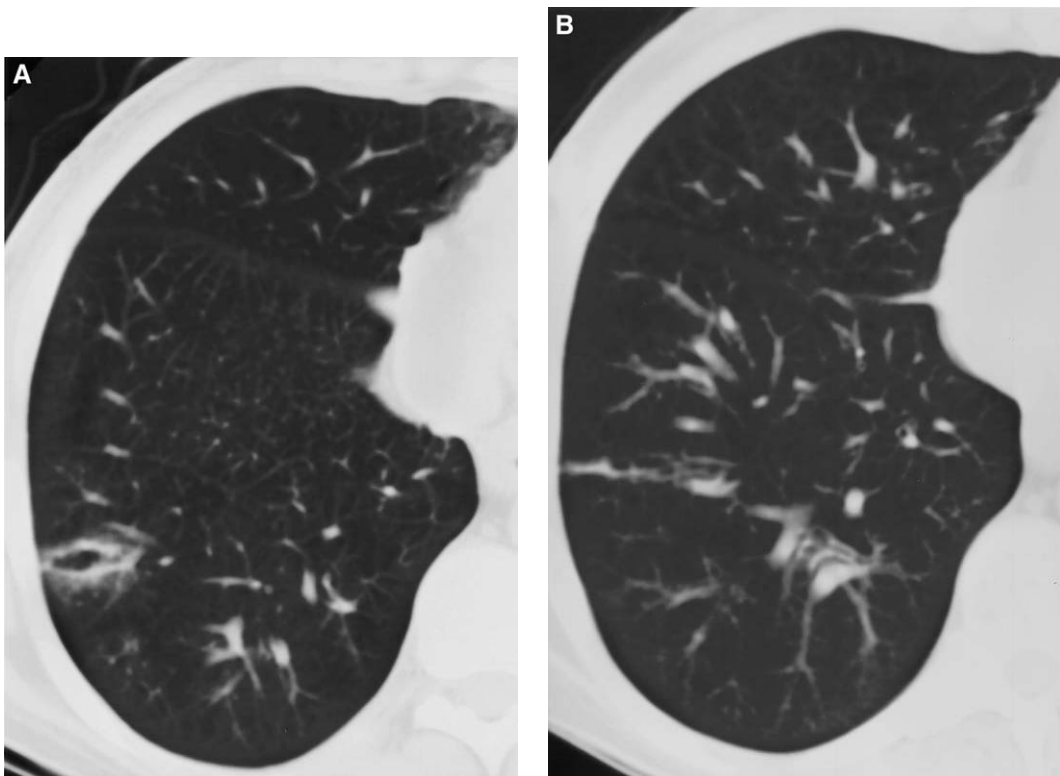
Transbronchial biopsy lung injury that mimics a cavitary lesion. (A) CT image immediately following the transbronchial biopsy shows a new cavitary lesion in the right lung that corresponds with the biopsy site as well as areas of ground glass attenuation that could be due to hemorrhage from the biopsy or lavage fluid. (B) The cavitary lesion and areas of ground glass attenuation have resolved on this CT taken 14 days later.
